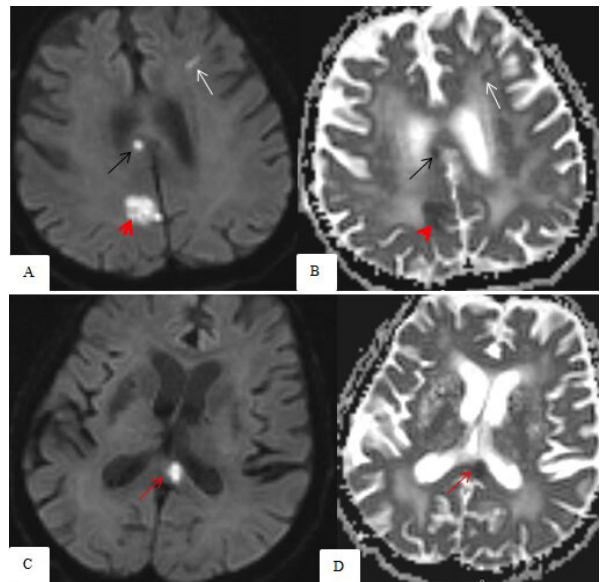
A 92-year-old female patient with with hypertension who presented with COVID-19 pneumonia and followed in ICU. A) DWI and B) ADC mapping of the brain show multifocal restricted diffusion at the left anterior corona radiata (A,B white arrow), at the right parasagittal frontal (A,B black arrow) and parietal lobes (A,B red arrow head), at the splenium of corpus callosum (C,D red arrow)
